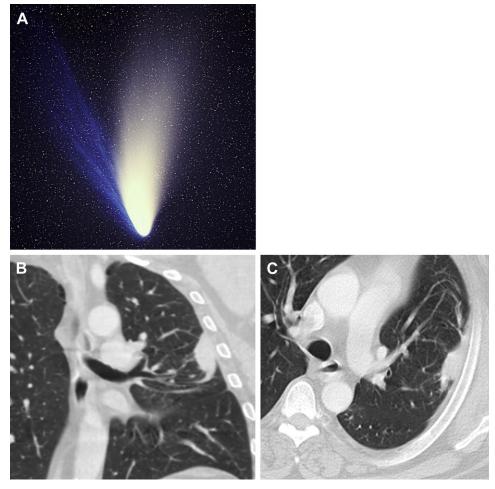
A, Image showing comet Hale-Bopp (by E. Kolmhofer, H. Raab; Johannes-Kepler-Observatory, Linz, Austria [http://www.sternwarte.at] [CC BY-SA 3.0 (http://creativecommons.org/licenses/by-sa/3.0)]), via Wikimedia Commons. B and C, Image showing comet tail sign in coronal and axial CT images, respectively, in a patient with rounded atelectasis.
